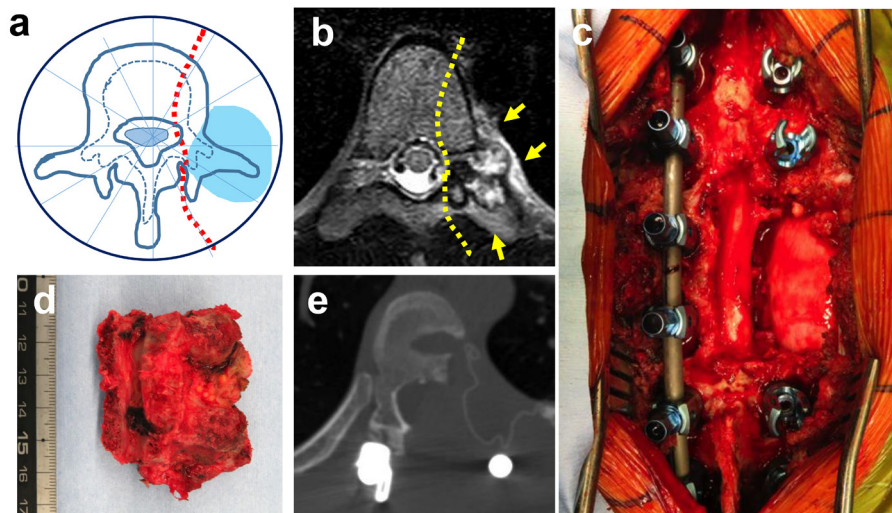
Representative case of sagittal resection. (a) A 24-year-old female with T9 chondrosarcoma (Grade II), WBB2-4, showing tumors present in layers A, B, and C. Dashed line indicates the planned resection line. (b) T2-weighted MRI image. Dashed lines indicate the planned resection lines and arrows indicate the tumor. (c) Intraoperative gross findings, showing combined resection of the chest wall and vertebrae, with exposure of the dura mater and lungs. (d) Macroscopic view of resected tumor. (e) Postoperative axial CT image.
